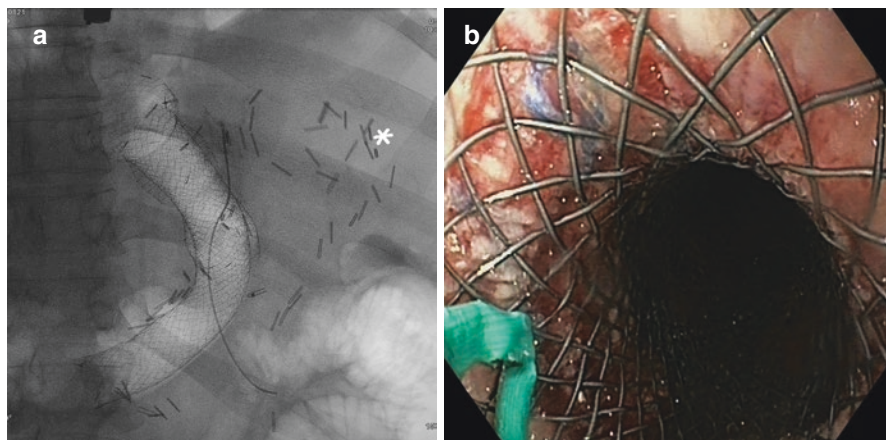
(a) Radiographic evaluation of a large-bore over-the-wire fully covered metal stent with a double antimigration system (Beta stent) for the treatment of a post-LSG leak: multiple surgical clips on the resection area (asterisk). (b) Endoscopic view of the proximal flange of the stent. LSG laparoscopic sleeve gastrectomy
